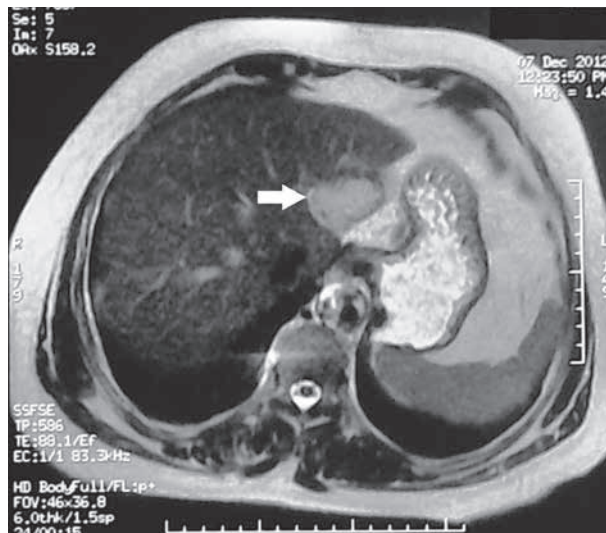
MRI demonstrating a homogeneous lesion measuring 58 mm in diameter with low intensity signal on T1 weighted image (arrow).
